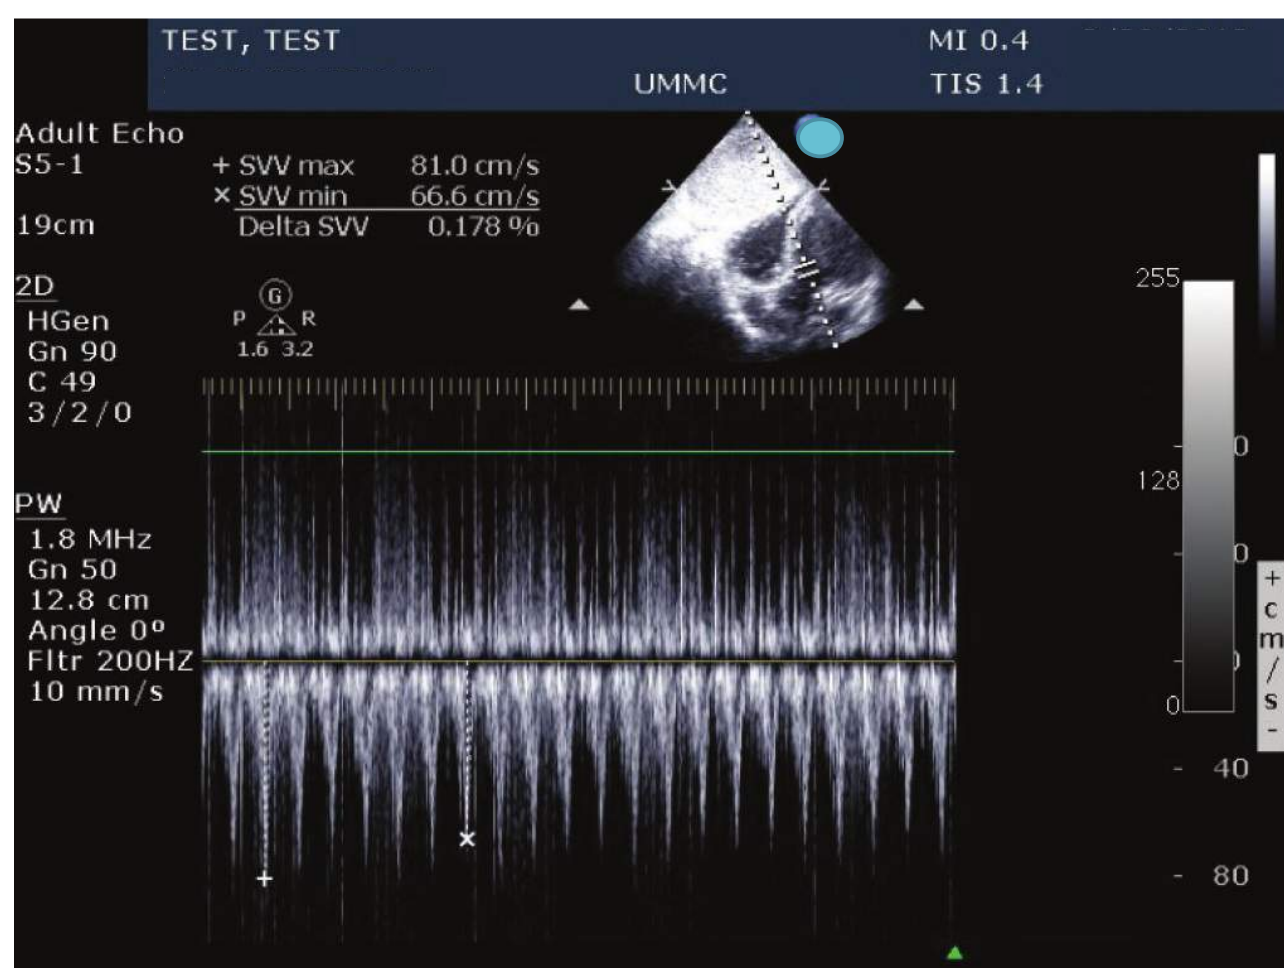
Doppler gate in the left ventricular outflow tract for stroke volume variation. The minimum and maximum velocity are used to calculate the delta.
